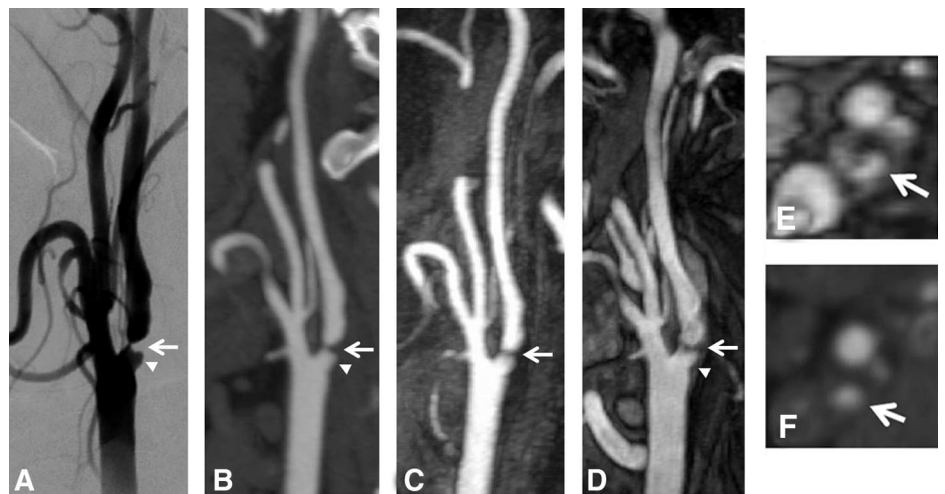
DSA (A) reveals a NASCET grade IV stenosis of the left ICA (arrows) with a deep ulceration of the plaque (arrowheads). Both findings are confirmed at CTA (B). The CE-MRA FP acquisition (C) correctly demonstrates the stenosis but fails to show the ulcer. The niche and its margins are, however, well defined on the SS MRA acquisition (D). Coaxial reformations from SS MRA (E) and CTA (F) show residual lumen (arrows). In this case the readers assigned a score of 2 for the usefulness of the SS acquisition (SS images provide additional diagnostic information over FP images potentially or definitely impacting the final diagnosis).
